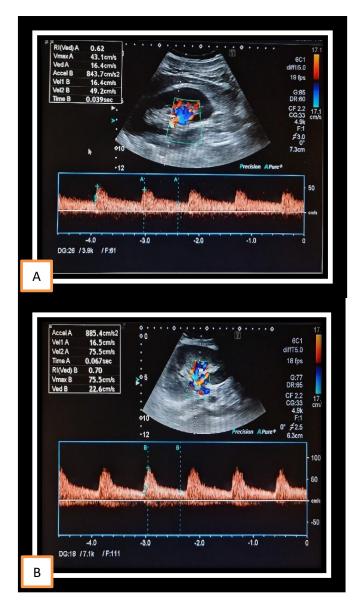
Renal RI during Doppler assessment of renal inter-lobar artery in hypertensive and normal controls. A, Renal RI in normotensive patient and B, Renal RI in hypertensive patient
